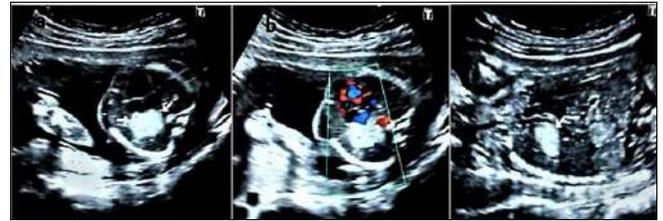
Type 3 congenital pulmonary airway malformation a. The axial view of the thorax. An echogenic mass in the right side of the lung. b. No visible vascularisation of the mass on doppler sonography. c. The saggital view of the thorax revealing supradiaphragmatic echogenic mass
